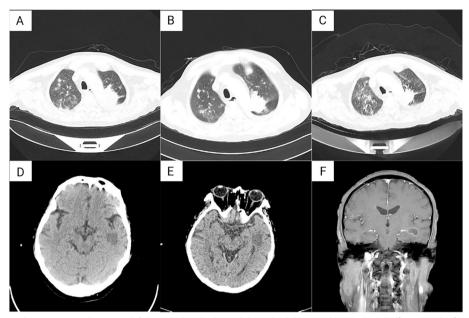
a Chest CT (Week 4): A mass in the upper left lung and multiple nodules in both lungs. Bilateral pleural effusion and inflammation in both lower lungs. b Chest CT (Week 5): Bilateral pleural effusion slightly reduced from before, with no other significant changes. c Chest CT (Week 6): A small amount of pleural effusion in the left side slightly reduced from before, with the rest remaining unchanged. d Brain CT (Week 4): Multiple low-density nodules were seen in the brain parenchyma, and the largest size was about 1.9 cm × 2.0 cm, which was located in the left temporal lobe. e Brain CT (Week 5): Similar to the previous, no significant changes. f MRI of the brain with contrast (Week 5): Multiple plaques and nodular lesions in the bilateral centrum semiovale, basal ganglia, and left temporal lobe
